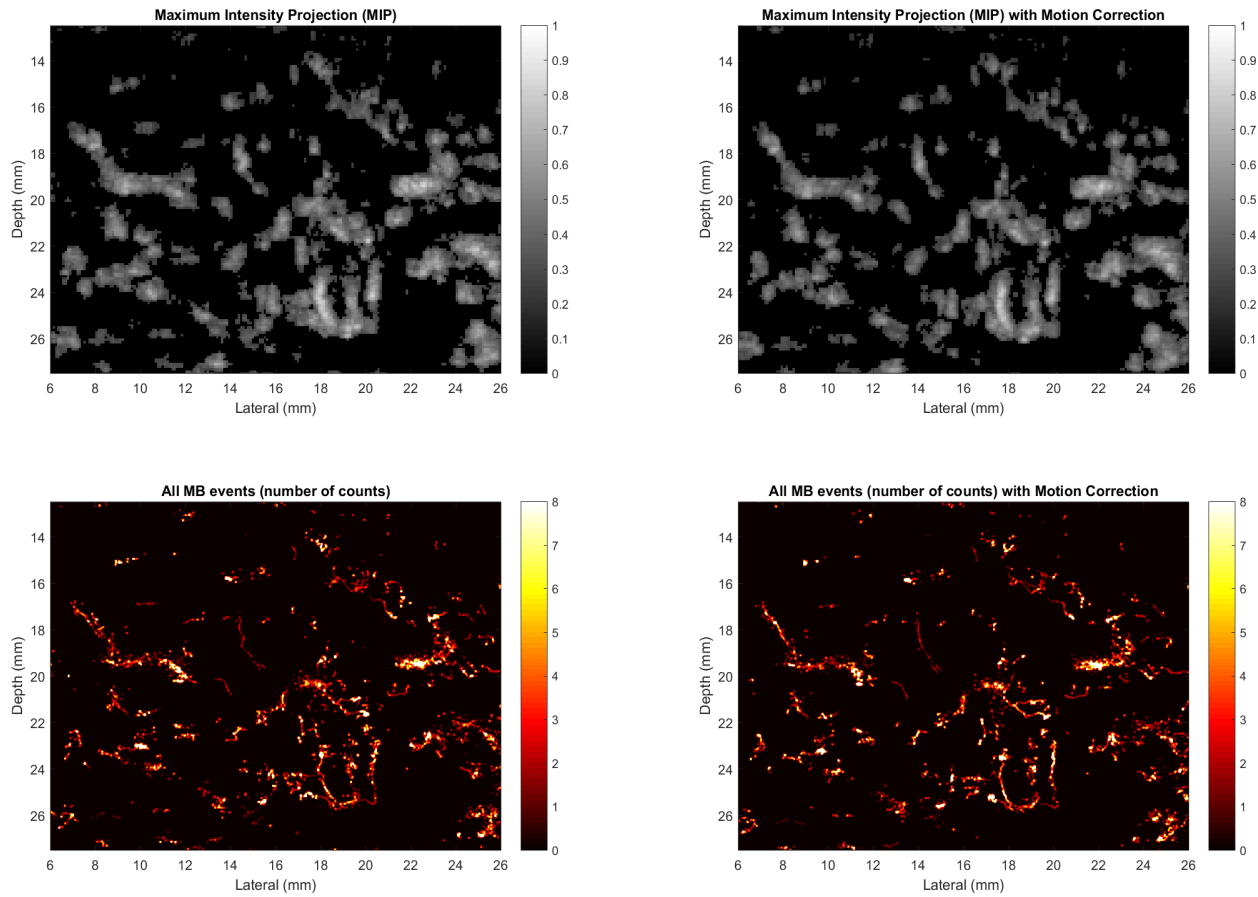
(Top-left) Maximum intensity projection of contrast enhanced ultrasound of human tibialis anterior muscle without motion correction and (Top-right) with motion correction. The colour bar corresponds to normalised intensity. (Bottom-left) All localised microbubble events are visualised without motion corrections and (Bottom-right) with motion correction. The colour bar corresponds to number of localisations.
